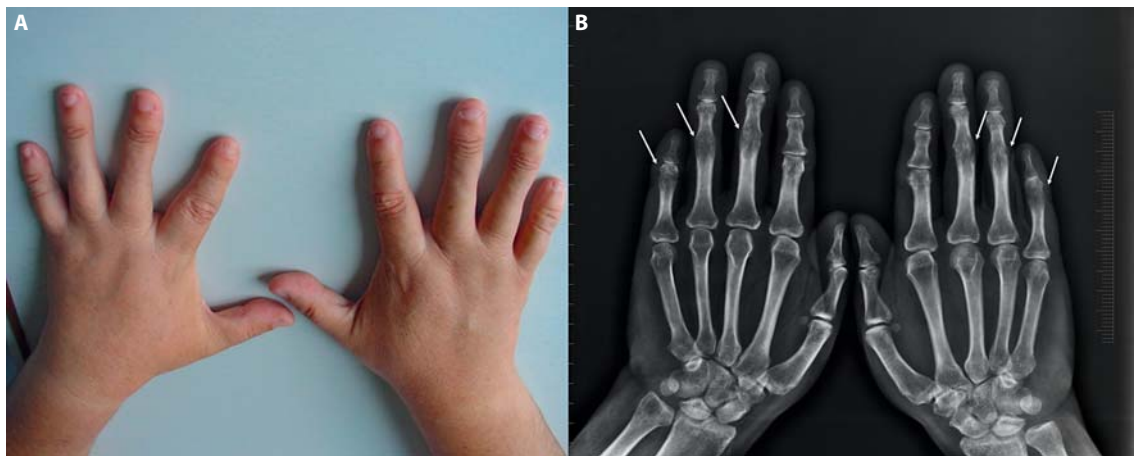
Hand view (A) and hand radiograph (B) of the proband with PIP joint synostoses of the 3rd–5th fingers bilaterally (arrows) and 5th finger brachymesophalangy.
